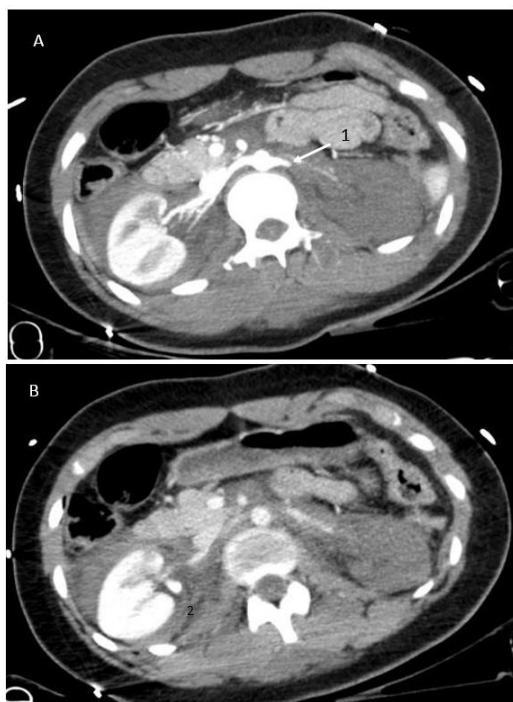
a y b: Axial slide of abdominal CT in arterial phase (a) and venous phase (b). Interruption of the contrast flow of the left renal artery (1) due to arterial dissection/thrombosis is observed. Right perirenal hematoma secondary to renal lacerations (2)
